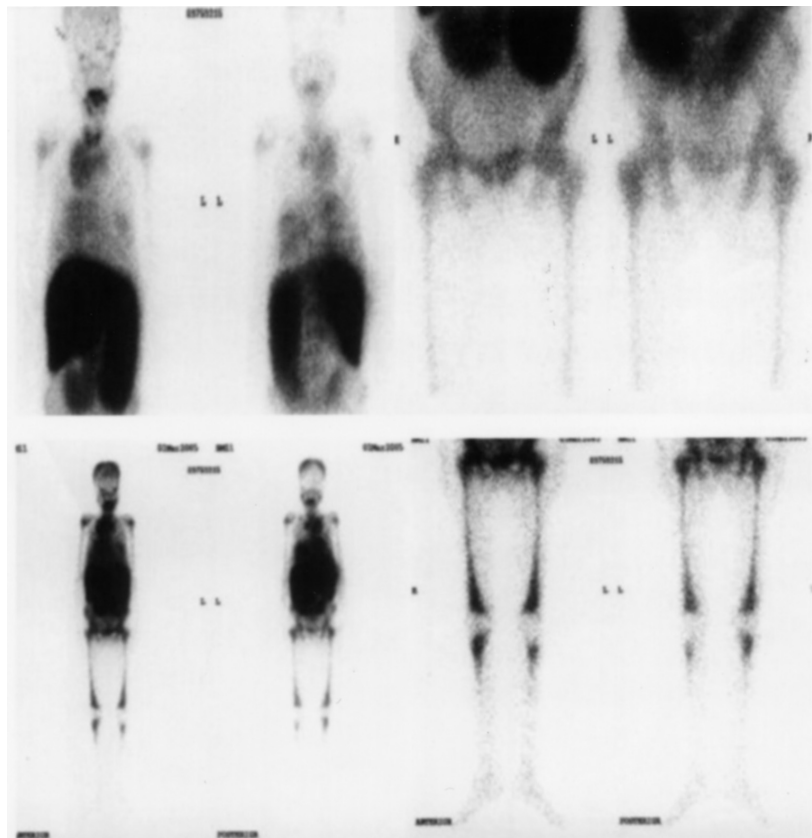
Tc99m sulfur colloid scintigraphy shows significant particle uptake in the mediastinum, lower thorax, and lower abdomen. Reactive bone marrow uptake in the distal femur and tibia is also demonstrated.
